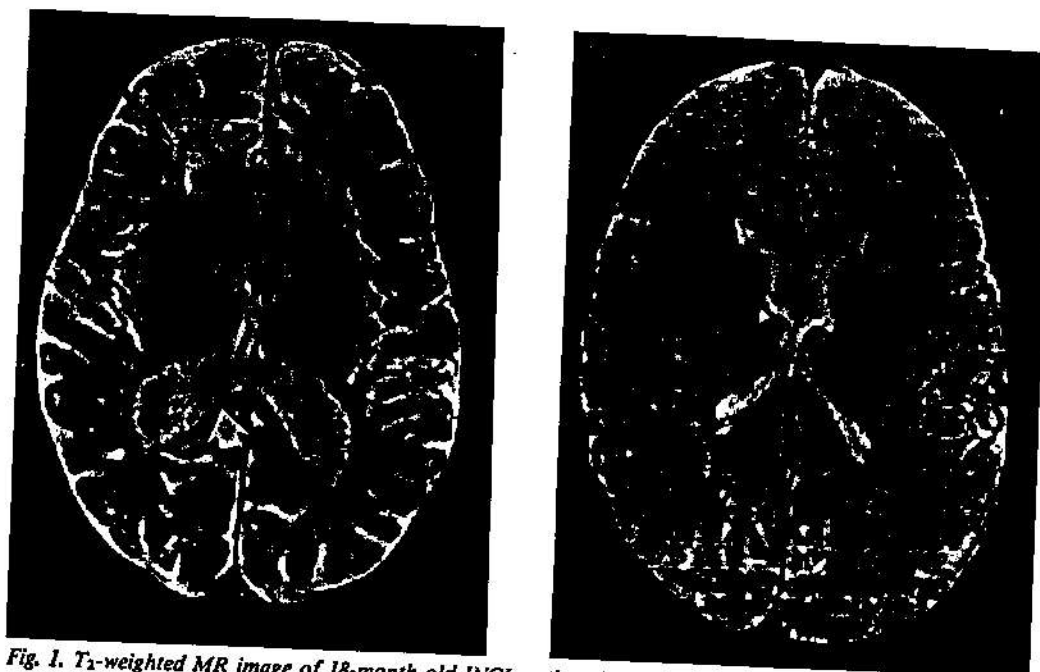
T<sub>2</sub>-weighted MR image of 18-month-old INCL patient (upper); image of 17-month-old child with normal brain (lower) presented for comparison. Lateral ventricles and sulci are dilated. Splenium of corpus callosum (white arrow) is thin. White matter is hyperintense in relation to cortical grey matter, while in normal brain peripheral white matter and cortical grey matter are isointense. Periventricular white matter (black arrow) has high signal intensity. Basal ganglia look hypointense and signal intensity in thalami is abnormally low.
